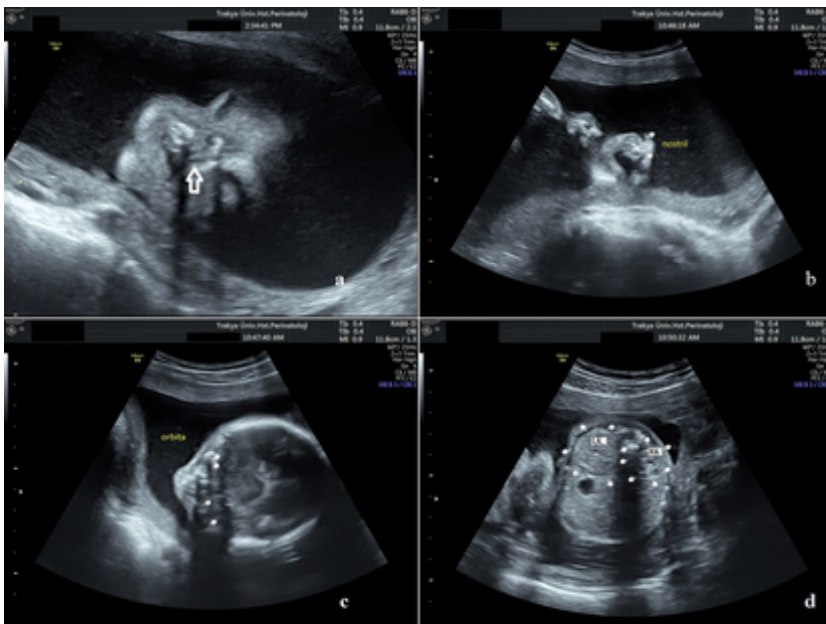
Ultrasonographic imagings of the fetus at 21 weeks of gestation. a,b. Bilateral broad cleft lip and palate (Arrow). c. Left anophthalmia and right microphthalmia. d. The different sizes between fetal kidneys. LK: Left kidney, RK: Right kidney
